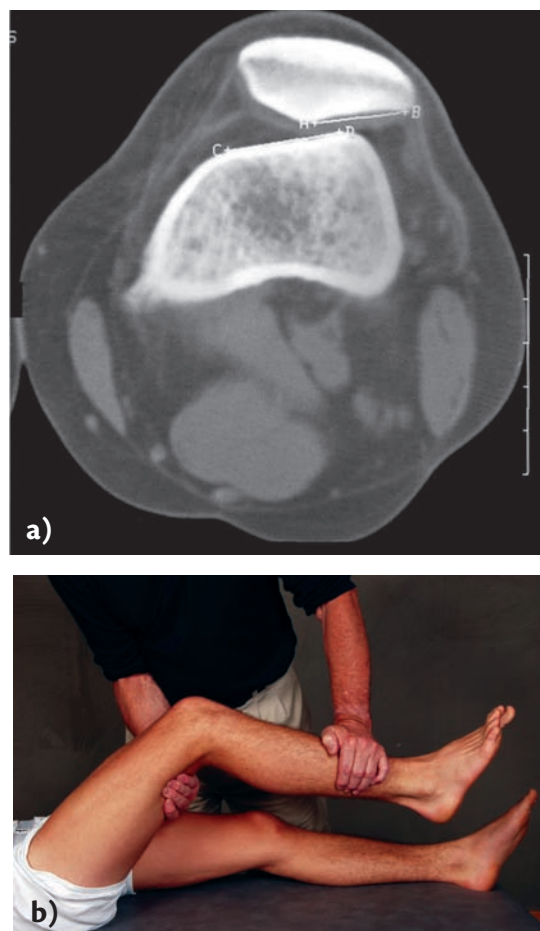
Computed tomography of the patellofemoral joint during contraction of quadriceps muscle. a) Cross-section of the knee, showing the patella subluxating relative to the femur with a flattened surface (thorochlea); b) during a quadriceps contraction the patella lateralizes on both sides.
